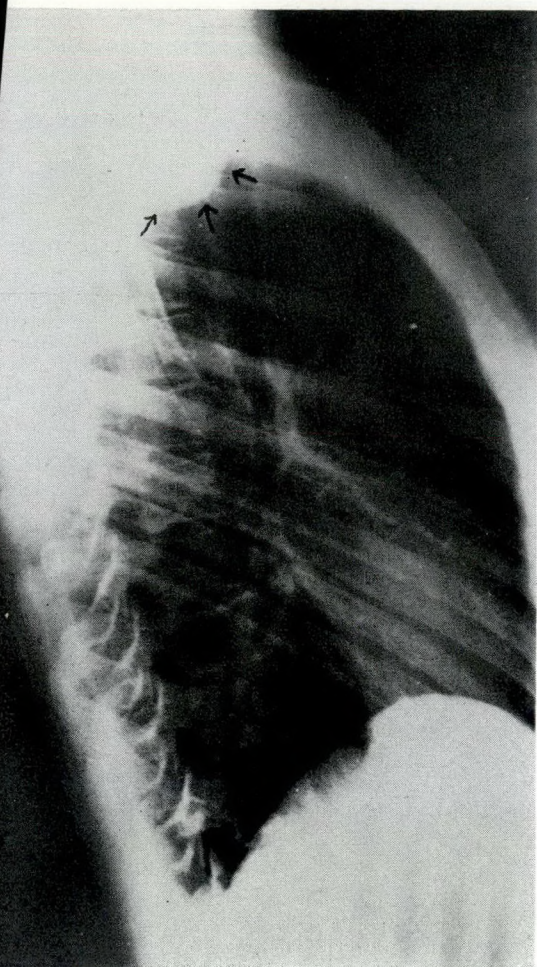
Mrs. L.B. Lateral radiograph of chest showing round lesion in right thoracic inlet area.
